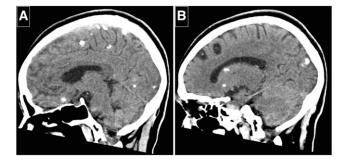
Computed tomography showing multiple calcifications and vesicular lesions in the frontal lobe (case 1).
